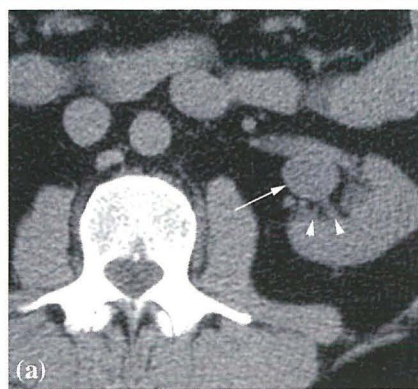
(a). Extrarenal pelvis. Axial CT scan shows apparent dilatation of the left renal pelvis (arrow), however note that the calyces are not dilated (arrow heads).
